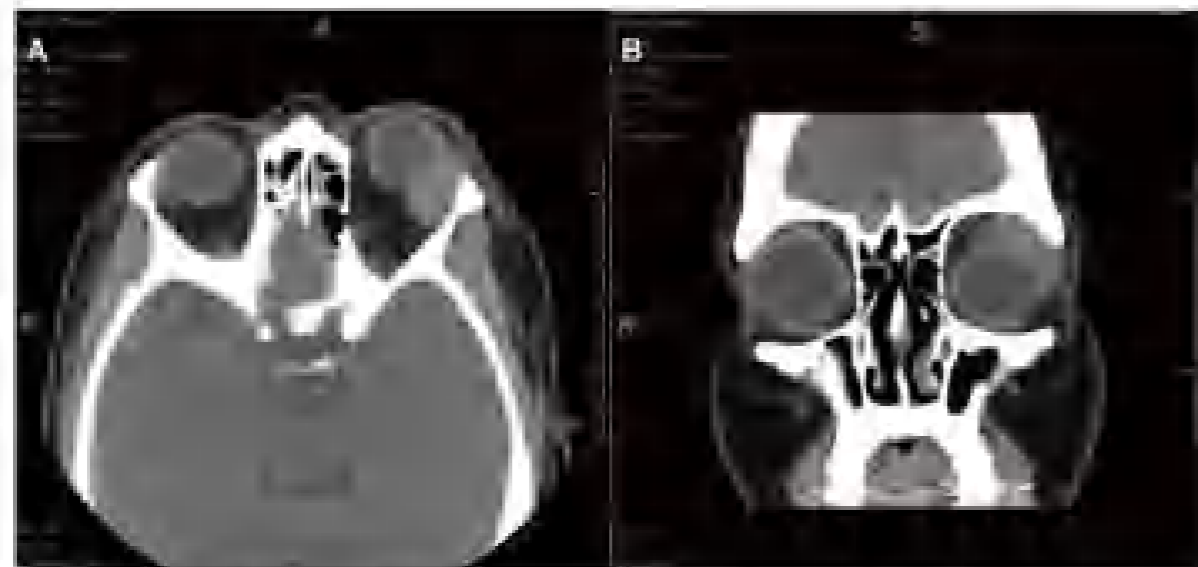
A, B, (A) Axial CT scan of the orbits with contrast shows enlargement of the left lacrimal gland on axial (A) and coronal (B) views.
